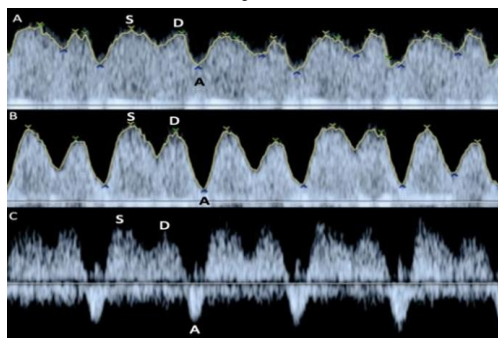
DV progression from normal to abnormal flow, producing the characteristic reversal in the A-wave. A: Normal ductus venosus Doppler flow waveform. B: Resistive A-wave, and C: reversed A-wave. Melber,⁹
